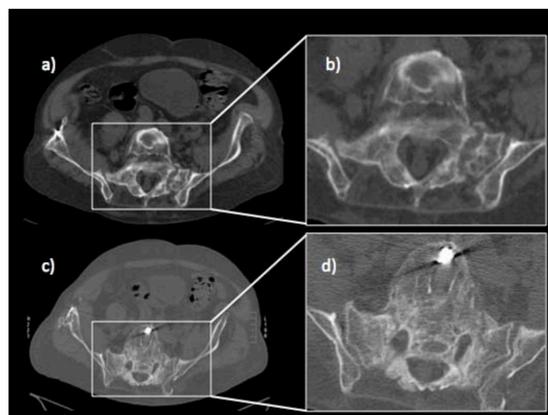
Monitoring of fracture healing by pelvic multislice computed tomography (MSCT): a) Axial overview at baseline b) zoom to bilateral sacrum fractures (li>re) at baseline c) Axial overview after 6 weeks treatment with teriparatide d) zoom showing healing in progress with fracture gap narrowing, new bone and callus formation.
